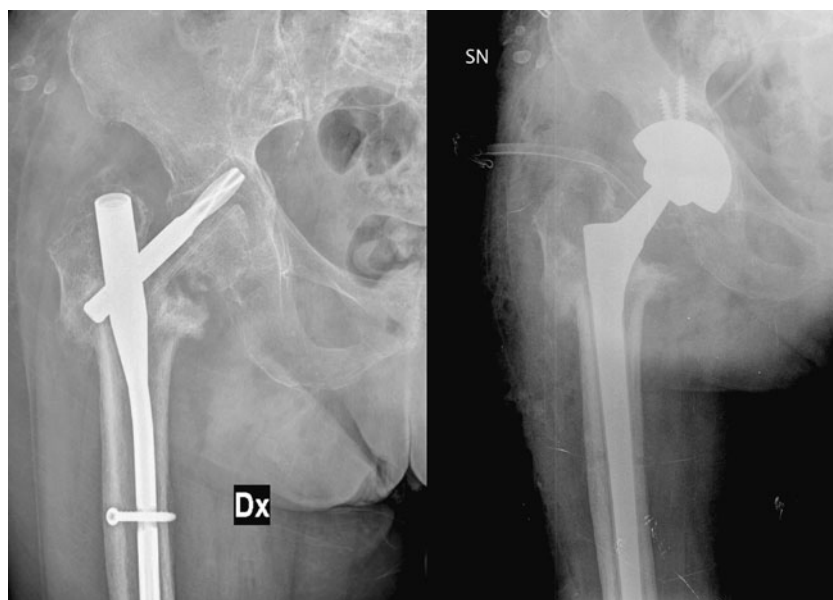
Pre and postoperative anteroposterior X-ray of a patient with migration of the neck screw
